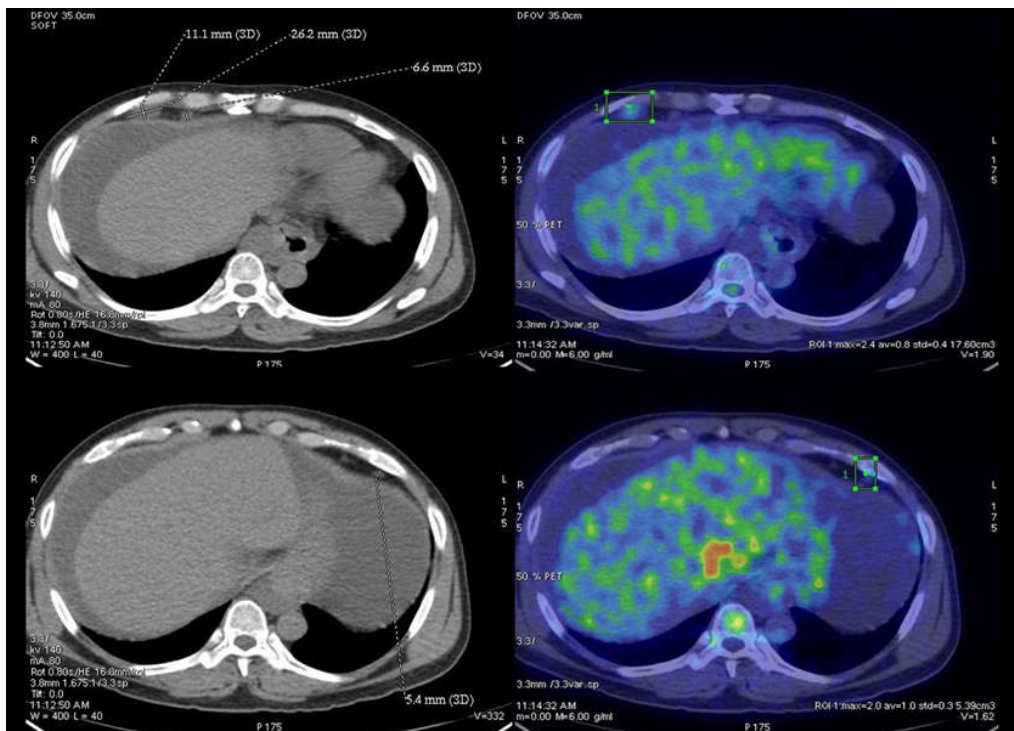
Fused axial images of FDG PET-CT showing mild metabolically active peritoneal nodules.
